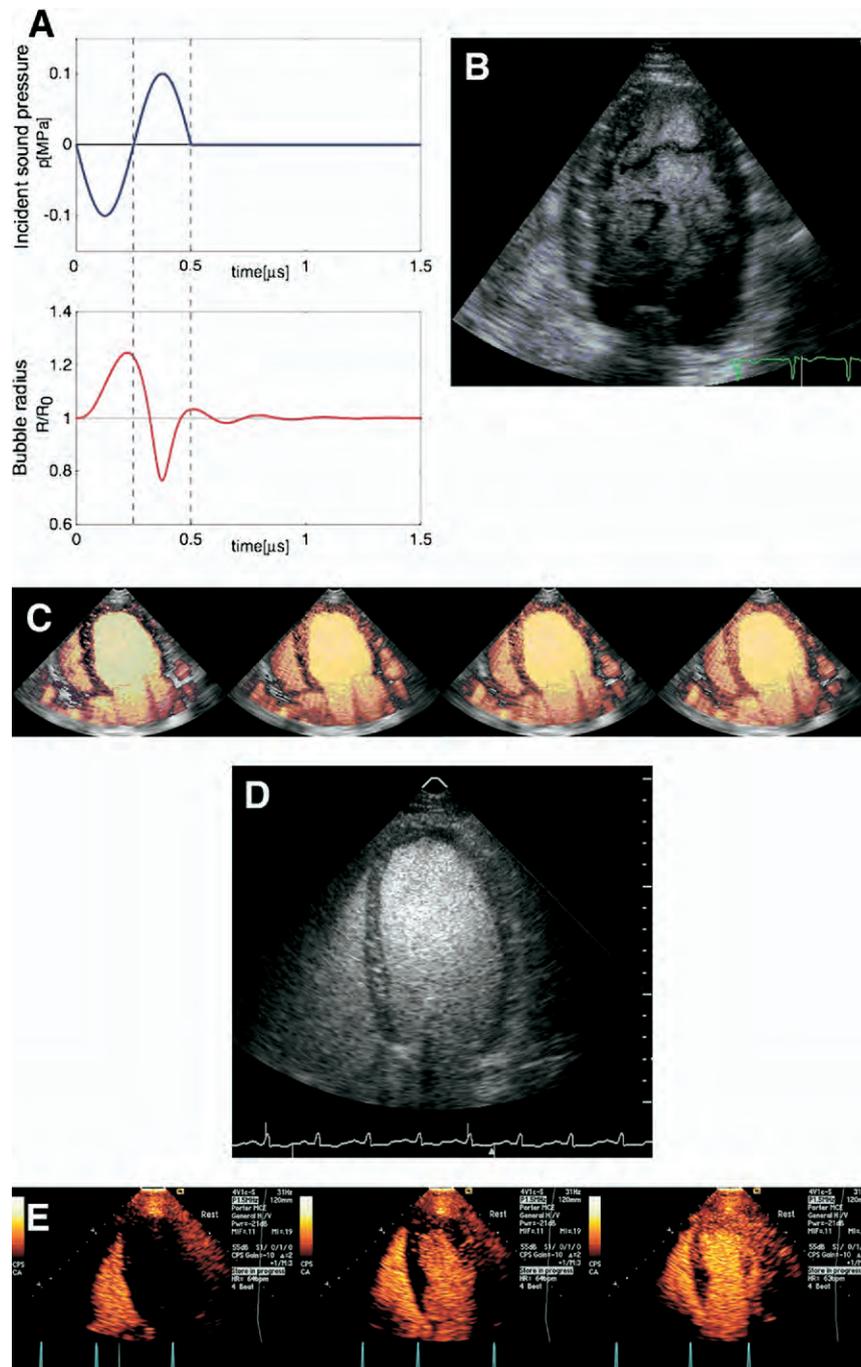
(A) Nonlinear bubble oscillation. When a microbubble is exposed to an acoustic field, its radius responds asymmetrically to the sound waves, stiffening when compressed and yielding a smaller change in radius. During the low-pressure portion of the sound wave, bubble stiffness decreases and radial changes can be large. This asymmetrical response leads to the production of harmonics in the scattered wave. (B) Pulse inversion image of LVO at high MI. Image shows the swirling artifact due to bubble disruption. (C) Disruption-replenishment perfusion imaging. High-MI intermittent power Doppler imaging of the left ventricle at pulsing intervals of 1, 2, 4, and 8 heartbeats. The myocardium enhances with increasing pulsing intervals, at a rate that reflects the blood flow rate of its perfusion. (D) Pulse inversion image of LVO at low MI. Uniform enhancement of the bubbles in the left ventricle is evident. (E) Low-MI, real-time imaging with contrast pulse sequencing to assess myocardial function and perfusion. Still-frame, apical 4-chamber images that were sequentially acquired (*left to right*) show contrast enhancement for function and perfusion assessment. *Left panel* shows start of IV injection of contrast agent, with the contrast medium entering the right ventricle. *Center panel* shows contrast within the LV cavity during the LVO phase, with clear endocardial border delineation. *Right panel* shows the myocardial phase with contrast seen in the myocardium.
